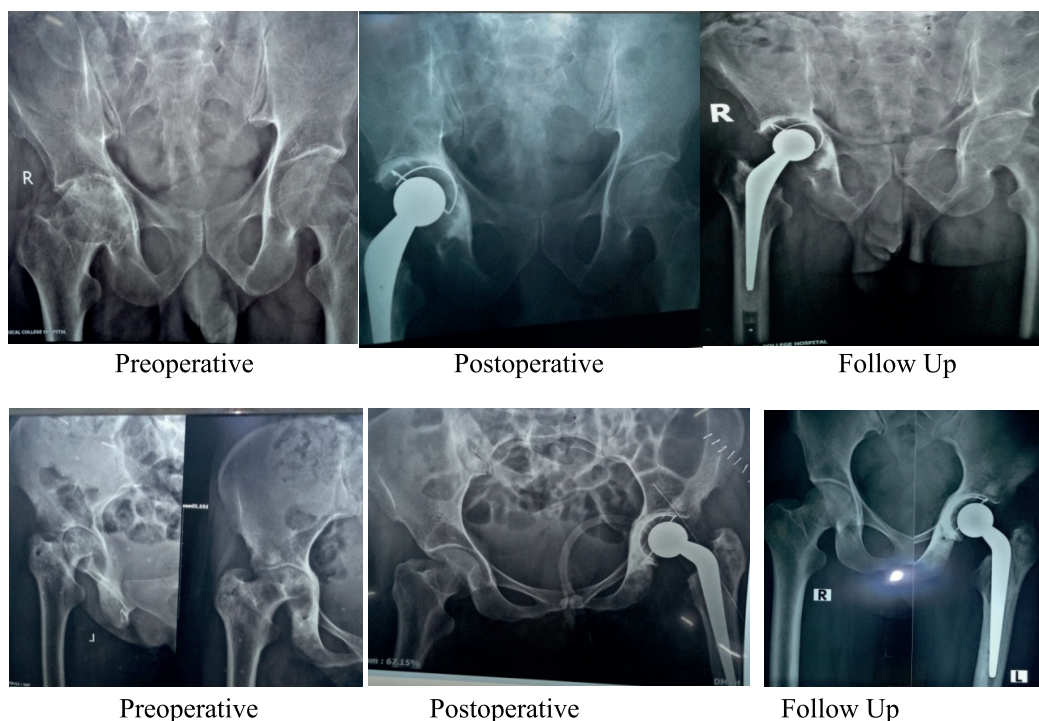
Pre-operative, Immediate post-operative and sixth week follow up X-ray of two different cases among the 7cases
